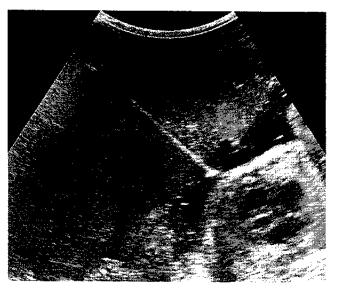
Percutaneous ultrasound-guided intrauterine transfusion at the site of placental cord insertion at 29 weeks gestation.
